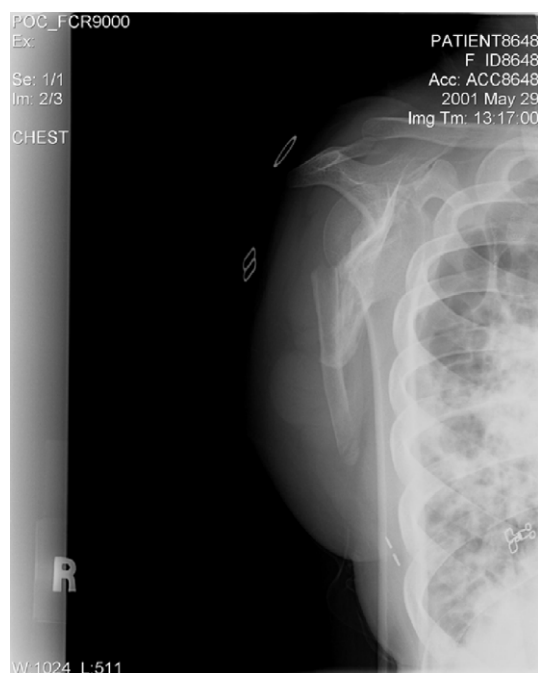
Radiograph showing scapular fracture as well as extensive disease in the right lung.
